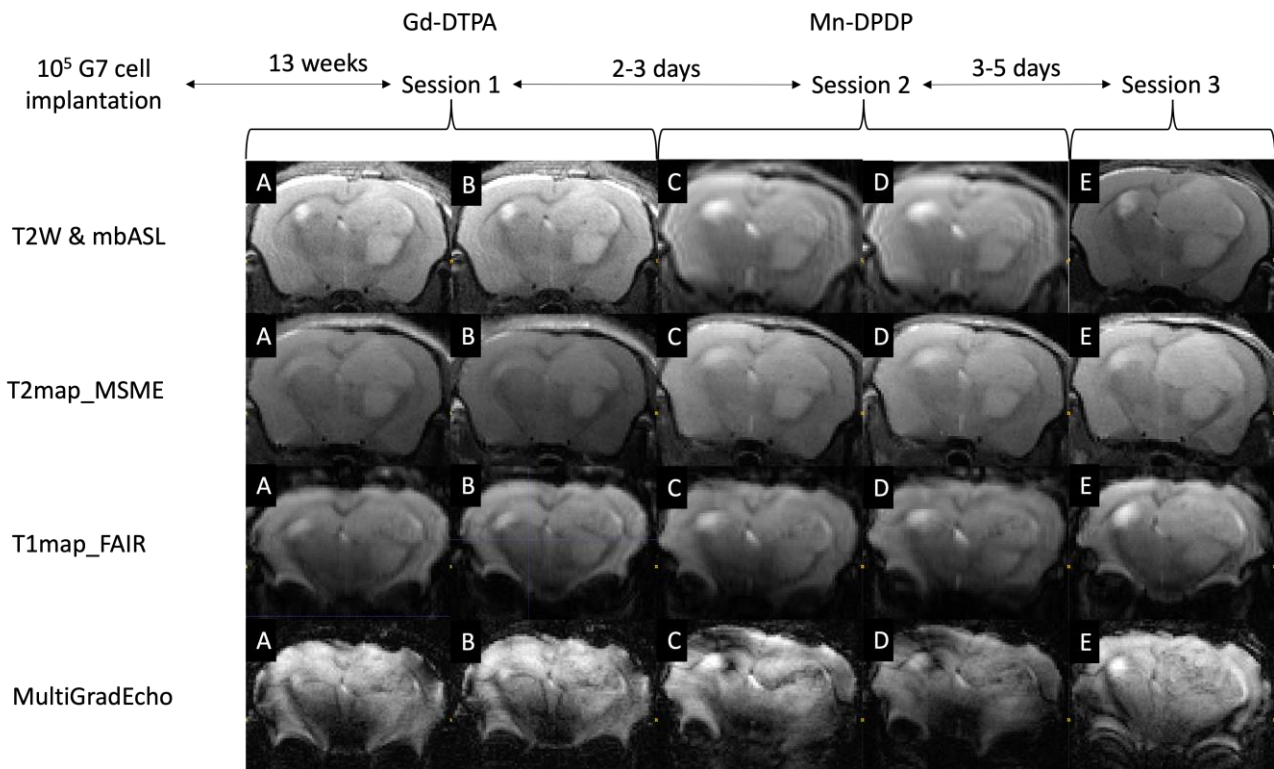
100 days (13 weeks) following G7 cell implantation, T2W, mbASL, T2map MSME, T1mapFAIR, and Multi Gradient Echo MRI images were obtained. 3 sessions were used to acquire the images. Images A and B, C and D, and E are from Sessions 1, 2, and 3, respectively. In sessions 1 and 2, images A and C stand in for pre-contrast agent images while B and D stand in for post-contrast agent images. Additionally, session 3 images were captured to assess the Mn delay rate after 3-5 days of contrast agent injection: hence, images with label E show Mn delay image
